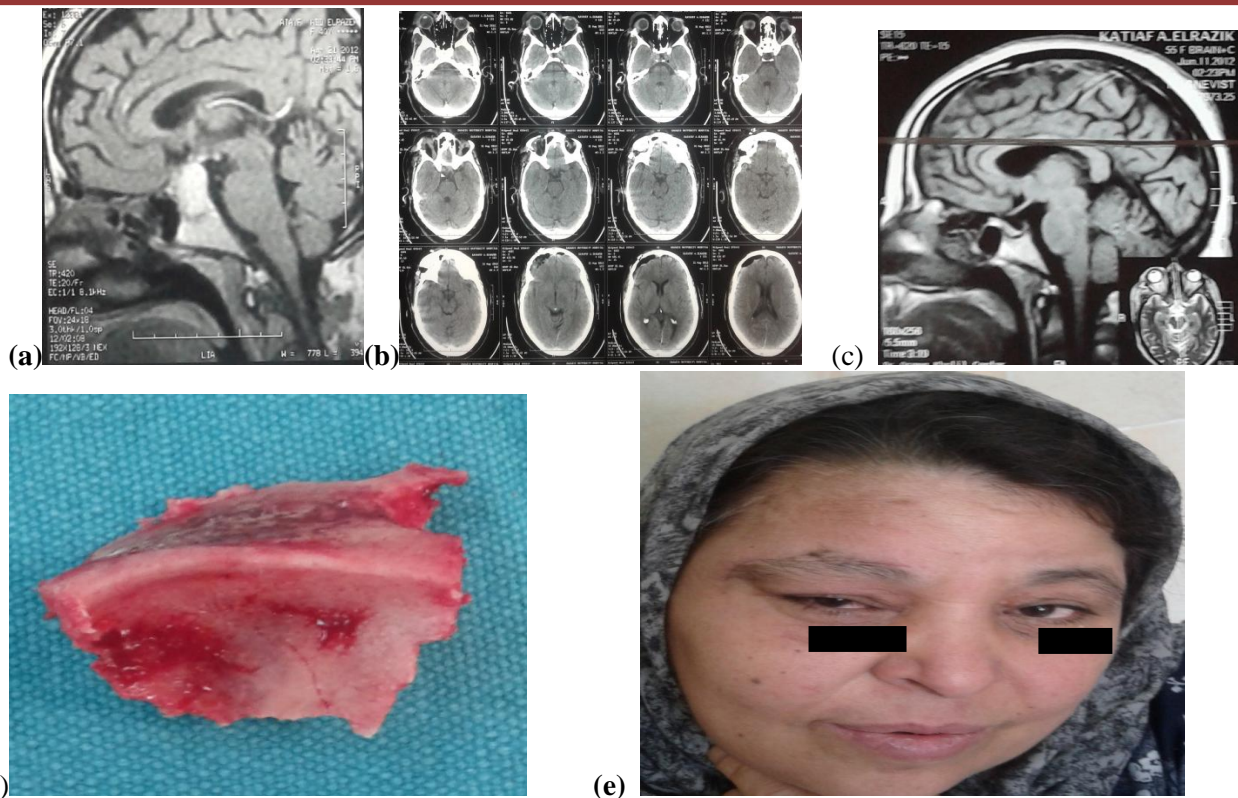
[a]preop.MRI pituitary macroadenoma, [b] CT 3 days postop., [c] MRI one month postop., [d] bone flap of the extended transsupraorbital craniotomy by orbital roof fracture., [e] patient one month postop.
